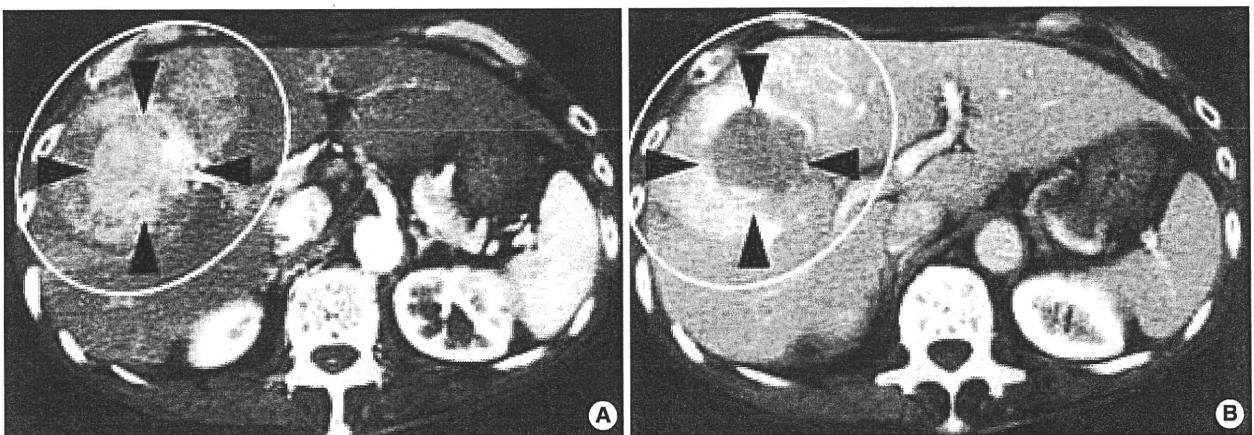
Computed tomography findings. (A) The tumor measuring 5 cm in diameter between the anterior inferior segment (S5) and the anterior superior segment (S8) of the liver showed hyper-enhancement (black arrow heads) in the early phase of dynamic enhanced CT accompanied with diffuse enhancement in the surrounding area (white circle). (B) It showed complete washout (black arrow heads) in the late phase with delayed hyper-enhancement in the surrounding area (white circle).
